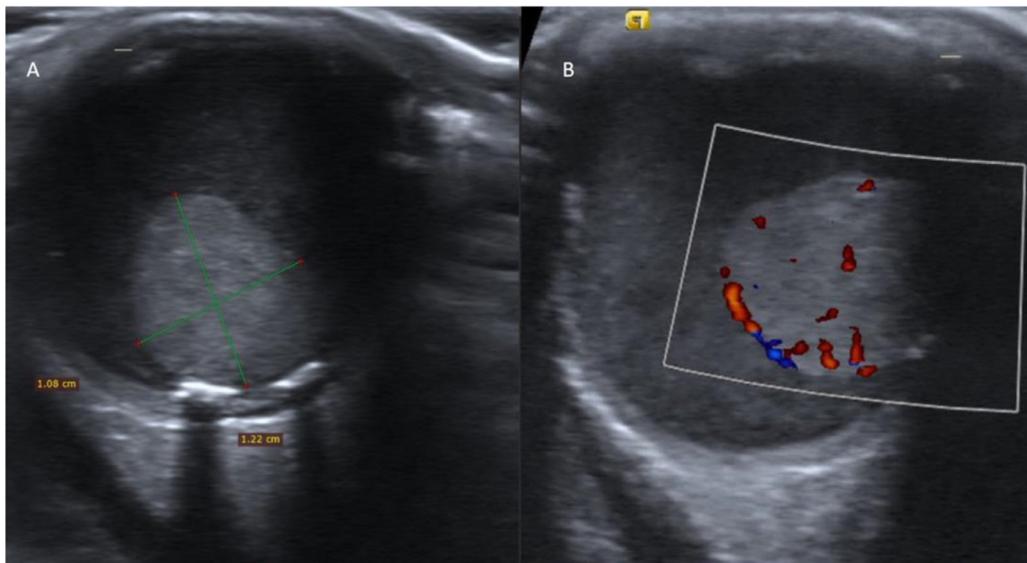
Ocular B mode ultrasound shows a heterogeneously hyperechoic multinodular mass lesion with foci of calcification (A) and internal vascularity (B).
